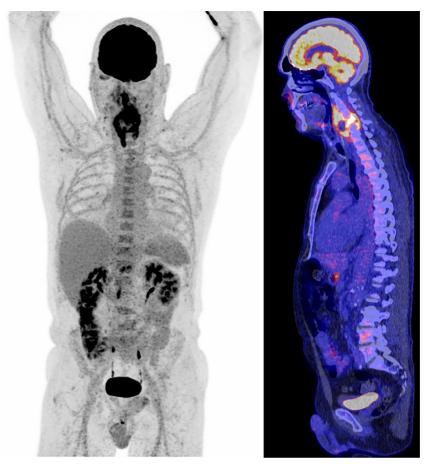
FDG-PET/CT (left MIP image, right sagittal FDG-PET/CT fusion image) of a patient with cervical spondylodiscitis with epidural and prevertebral abscesses.
